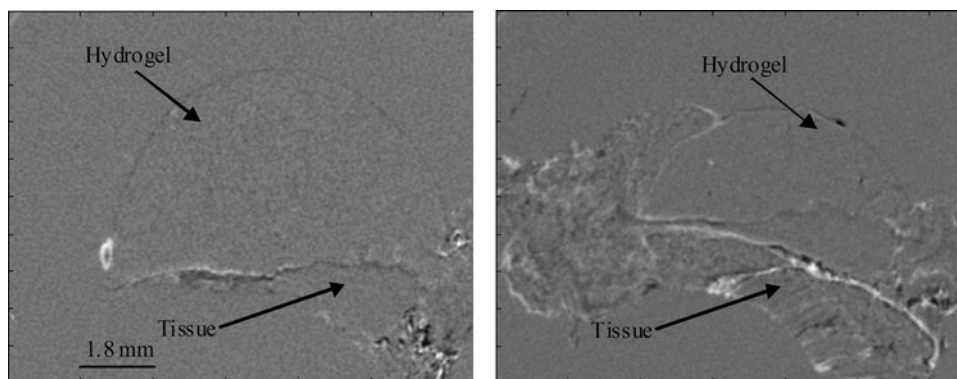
Refraction CT cross sections of explanted porous PEG hydrogels. The fibrovascular tissue and hydrogel can be clearly identified.
